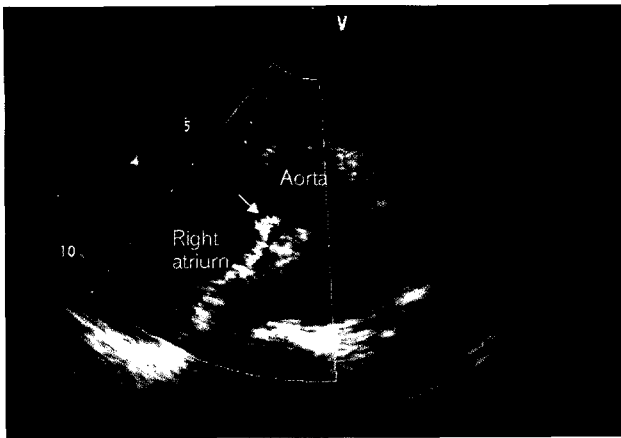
Transthoracic echocardiography in the parasternal short-axis view 2 months after the Amplatzer Septal Occluder implantation. The presence of the aorta-to-right atrial fistula (arrow) is confirmed.
